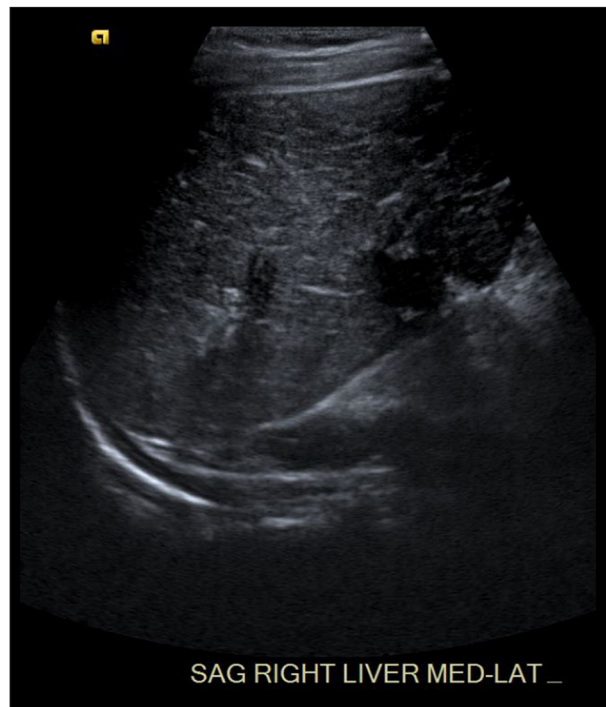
Transverse sonographic image of the liver demonstrates diffusely heterogeneous/coarsened architecture suggesting underlying hepatocellular disease.
